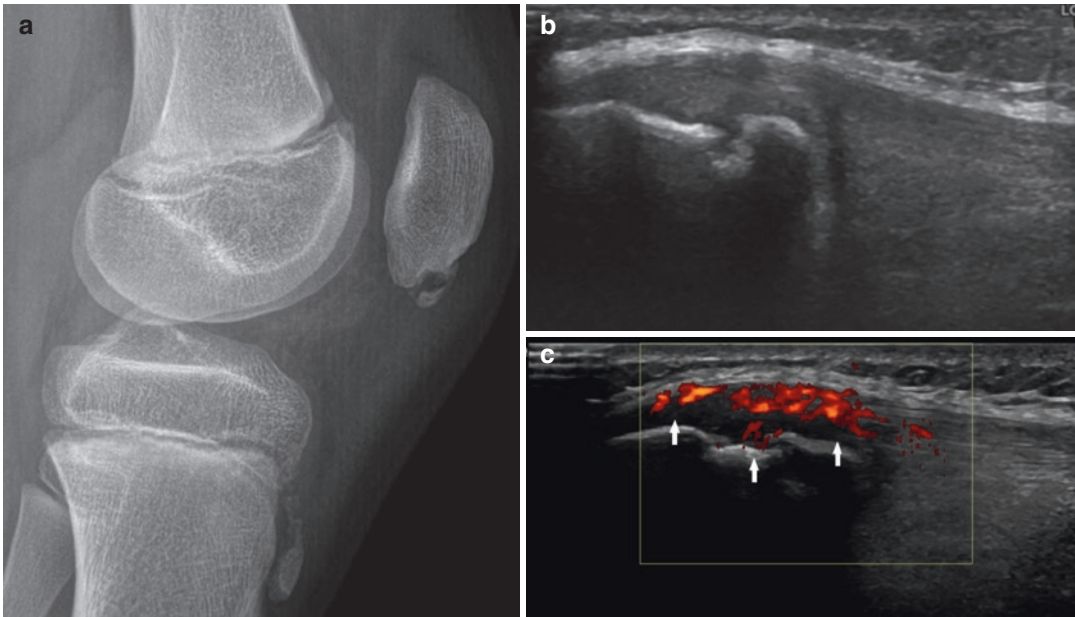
Jumper's knee. Ultrasound image demonstrating hypoechoic thickening of the proximal patellar tendon with intratendinous calcification
